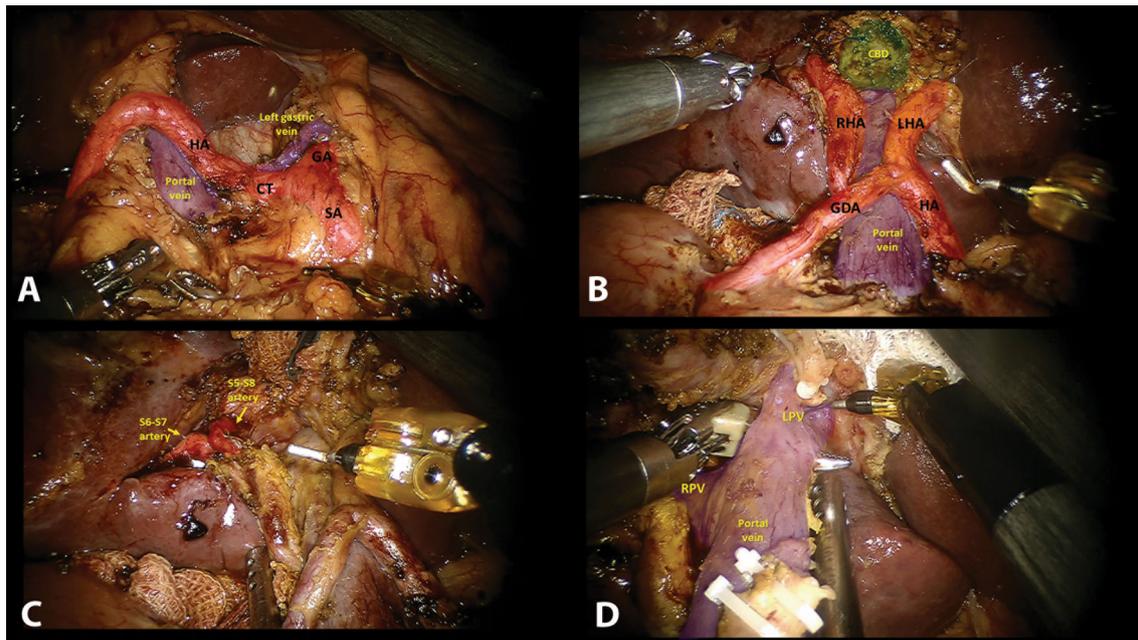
Robotic resection of hilar cholangiocarcinoma. a Intraoperative view after celiac trunk (CT) lymphadenectomy. GA left gastric artery, SA splenic artery, HA common hepatic artery. b Intraoperative view after hilar lymphadenectomy. GDA gastroduodenal artery, RHA right hepatic artery, LHA left hepatic
